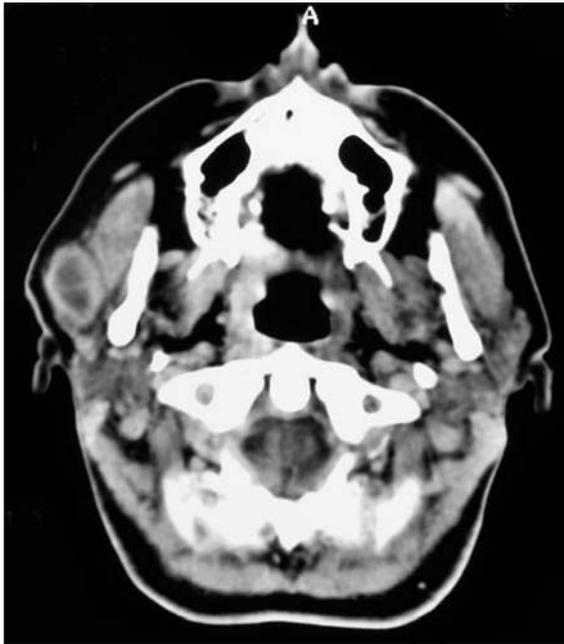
CT-scanning demonstrating a right parotid mass.
